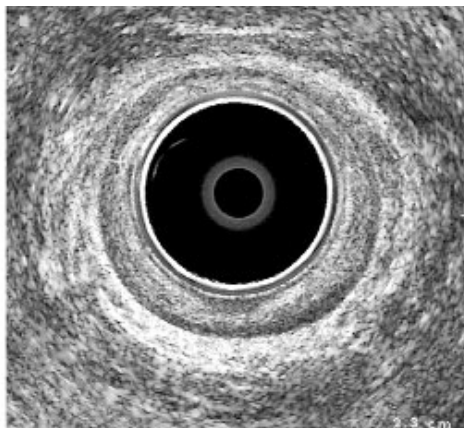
Endosonography with an axial image in the mid canal of an elderly patient, aged 73yrs with passive faecal incontinence. The internal sphincter measures only 1.1mm (markers) indicative of internal sphincter degeneration.
